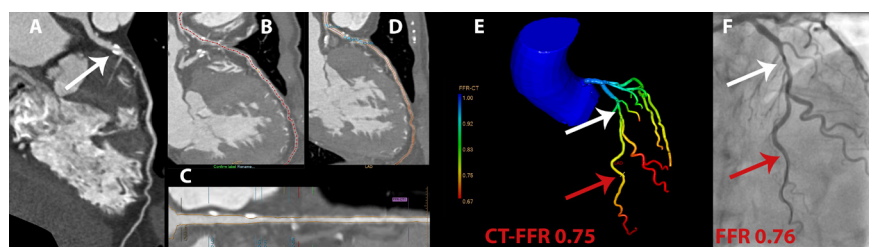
Case example of CT-FFR analysis. CCTA curved multiplanar reconstruction of the left anterior descending artery (A) indicated a significant stenosis (white arrow; 50-69% degree of stenosis). To apply the CT-FFR algorithm first the centreline was automatically segmented and manually corrected where needed (B), subsequently automatic lumen segmentation was performed and also manually corrected where needed (C + D). This anatomical model of the coronary tree was used as input for the CT-FFR algorithm. In this case, CT-FFR (E) was 0.75 (red arrow), indicating a significant stenosis (white arrow). Findings were confirmed by invasive FFR (F) with a value of 0.76 (red arrow). CCTA = coronary computed tomography angiography; CT-FFR = coronary computed tomography angiography-derived fractional flow reserve; FFR = fractional flow reserve
